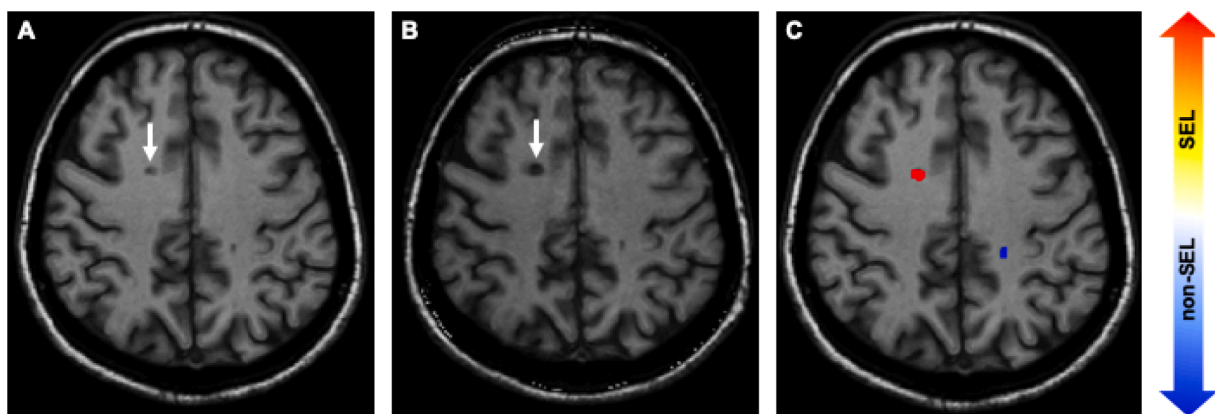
Example of patient with SEL and PBH. Example of patient enrolled in the study (53 years old at baseline with RRMS and EDSS 4.5, progressed to 6.0). Image A is the baseline T1-weighted scan, image B is the follow-up scan. The white arrow indicates a lesion that was T1 hypointense at baseline and over a follow-up of 9.3 years thus represent a PBH, and in C the Jacobian map indicates that the same lesion corresponds to a SEL.
